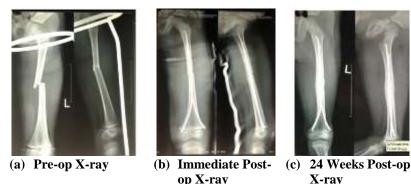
(a) Pre-op, (b) Immediate Post-op, (c) 24 Weeks Post-op X-ray
